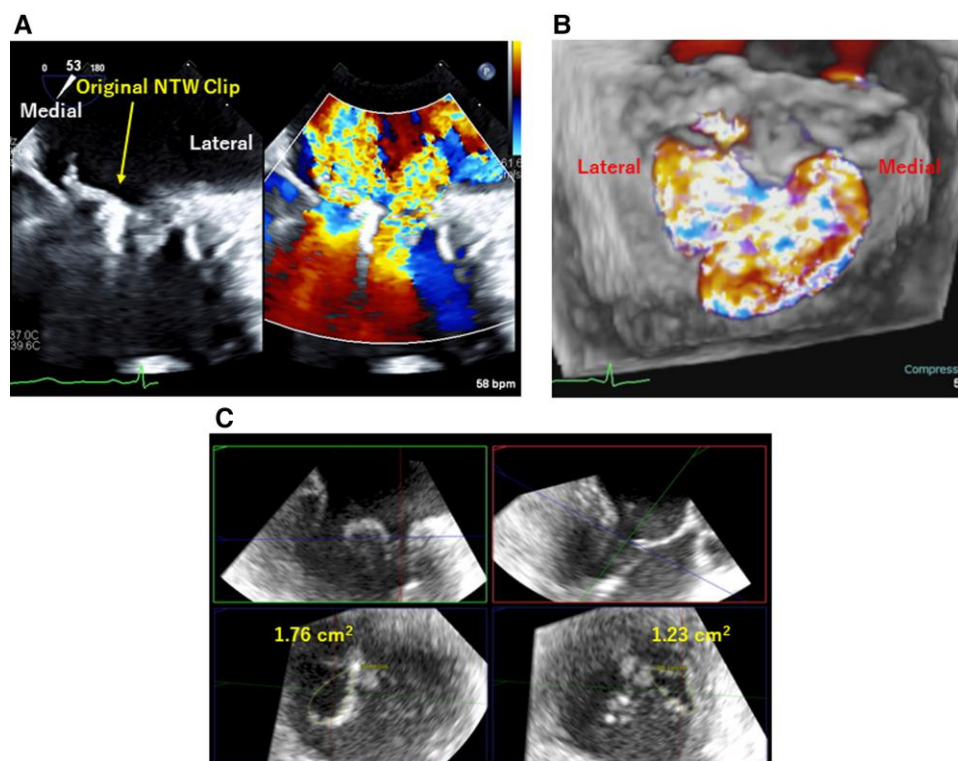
Transoesophageal echocardiography images 6 months after the first clipping. (A) Severe recurrent mitral regurgitation is observed from both sides of the clip in the inter-commissural view. (B) Mitral regurgitation is confirmed on three-dimensional colour imaging. (C) The mitral valve area calculated by three-dimensional multiplanar reconstruction is 2.99 cm².
